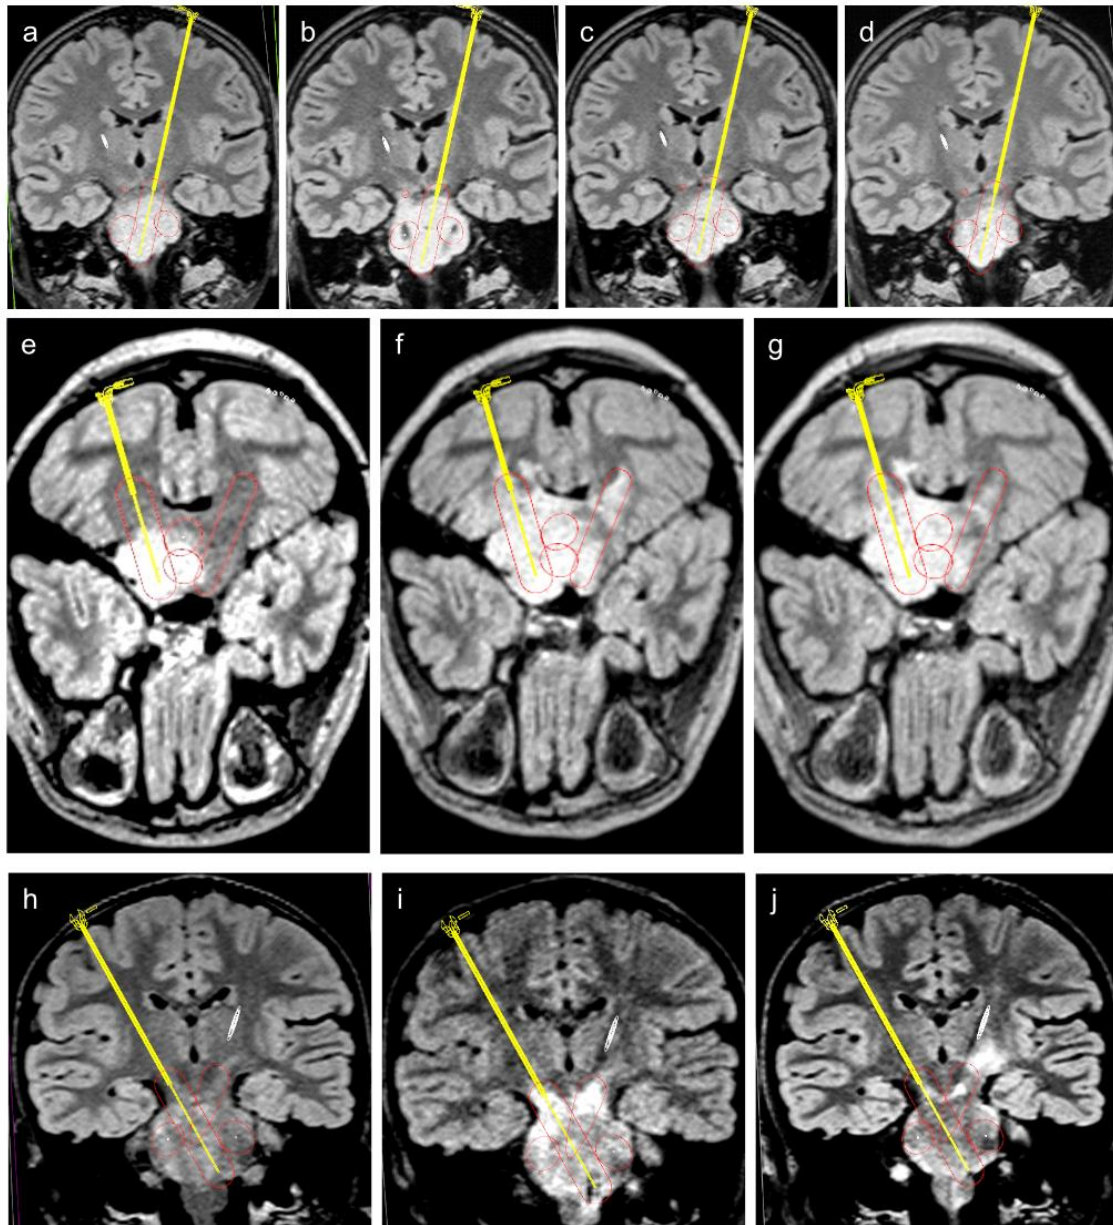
Radiological changes in patients receiving pontine infusion of carboplatin and sodium valproate by chronic intermittent convection enhanced delivery (CED) for the treatment of diffuse intrinsic pontine glioma (DIPG). Fluid attenuated inversion recovery (FLAIR) sequences along the left frontal trajectory are shown for Patient B at implantation (a) and after infusion demonstrating drug distribution within the pons (b). After treatment with 4 cycles of sodium valproate monotherapy the tumour was unchanged (d) at 14 months following diagnosis after 5 cycles of combined therapy volume and signal within the pons had reduced (d). FLAIR sequences are shown along the trajectory of the left cerebellar catheter at implantation in Patient L (e), after the third cycle of CED, demonstrating increased intensity within the treatment volume (f) resolving 12 weeks later (g). FLAIR sequences for Patient J along the right frontal trajectory are shown at implantation (h) after infusion demonstrating distribution of drug (i) and development of thalamic disease 9.9 months after diagnosis (j).
